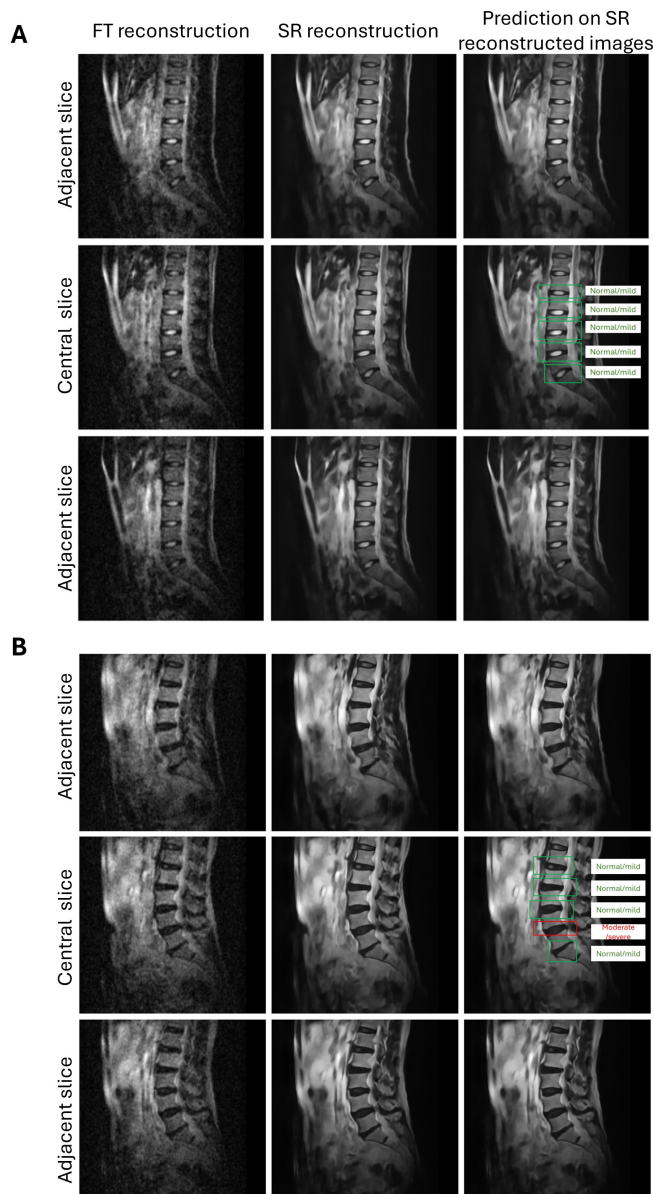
IVDD detection of experimental 0.05 Tesla ULF MRI data from (A) one healthy subject and (B) one subject with disc degeneration in the per-lesion level. The first column is the raw experiment 3D FT reconstructed ULF images. The second column is the corresponding SR reconstructed images. The third column is the IVDD detection results on the corresponding SR reconstructed images. The detection model could correctly localize discs of interest and classify the labels for each disc for both two subjects on the SR reconstructed images.
